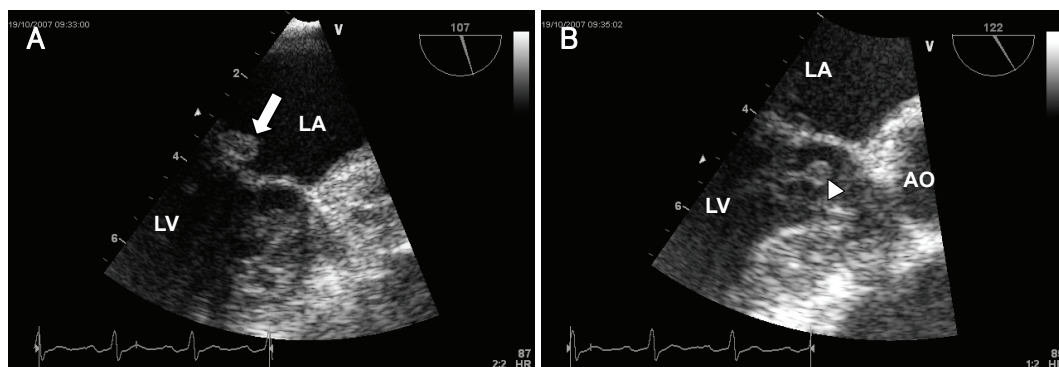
Transesophageal echocardiography findings. Multiple vegetations are attached to the posterior mitral valve (A: white arrow) and chordae of the anterior mitral leaflet (B: arrow head). LA: left atrium, LV: left ventricle, AO: aorta.
